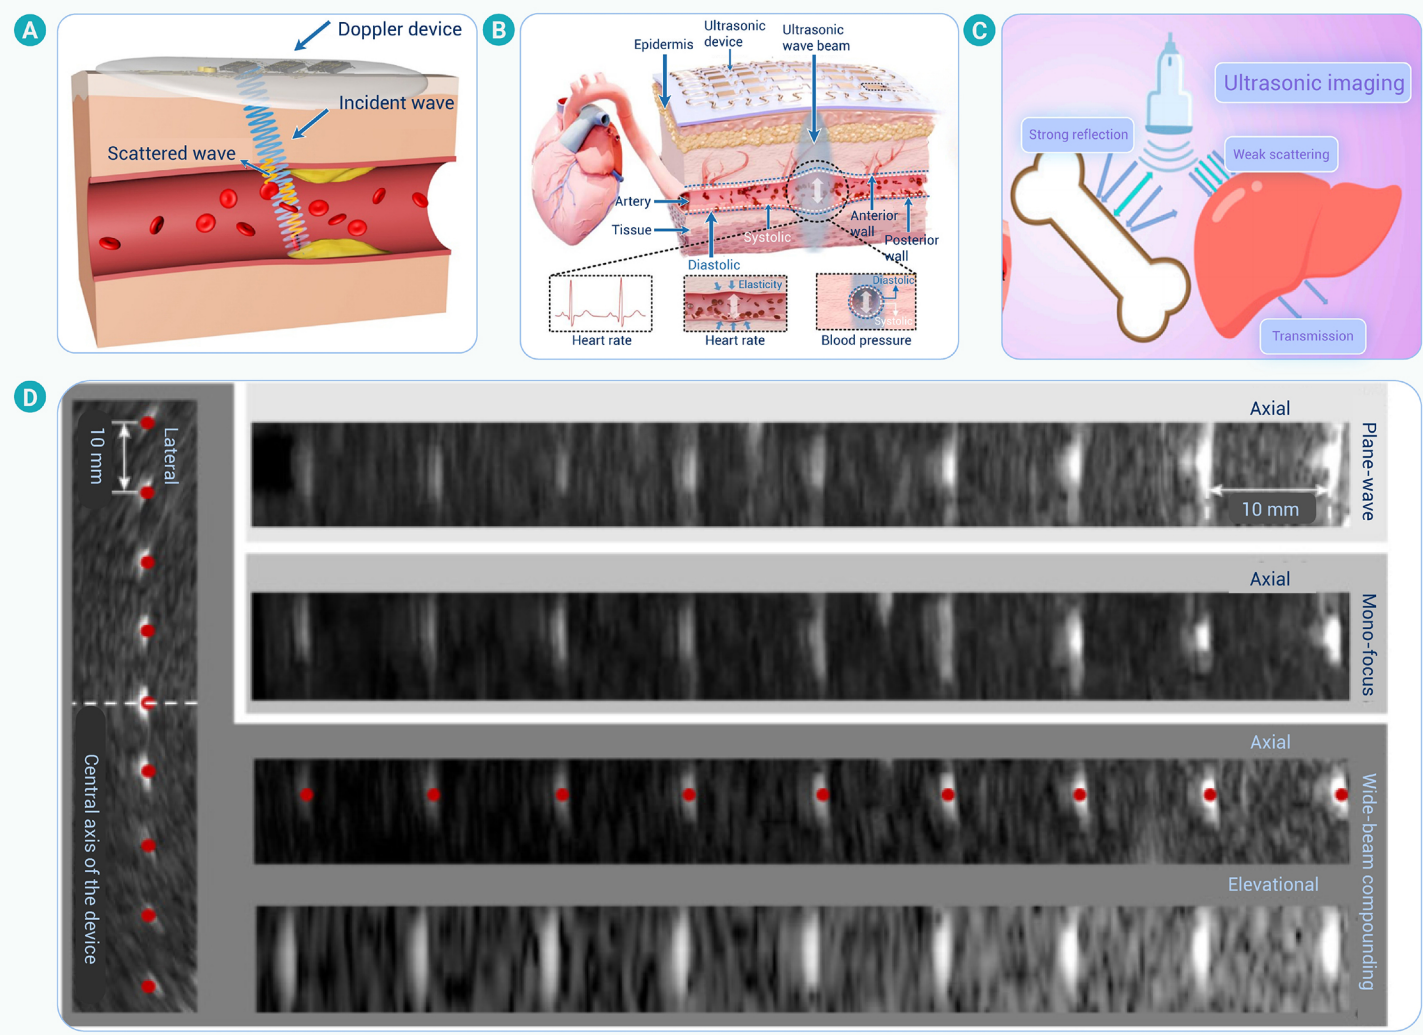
Working principles of the flexible ultrasound patch (A) Principle of monitoring blood flow and blood pressure in vessels; Modified appropriately and reproduced with permission.²² Copyright 2021, American Association for the Advancement of Science. (B) Working principle of obtaining hemodynamic parameters through ultrasonic Doppler sensing; Modified appropriately and reproduced with permission.²² Copyright 2025, American Association for the Advancement of Science. (C) Principle of imaging internal human tissues using ultrasound; Modified appropriately and reproduced with permission.²⁷ Copyright 2025, MDPI. (D) The comparison of three transmit beamforming strategy; Modified appropriately and reproduced with permission.¹⁹ Copyright 2023, Nature.
